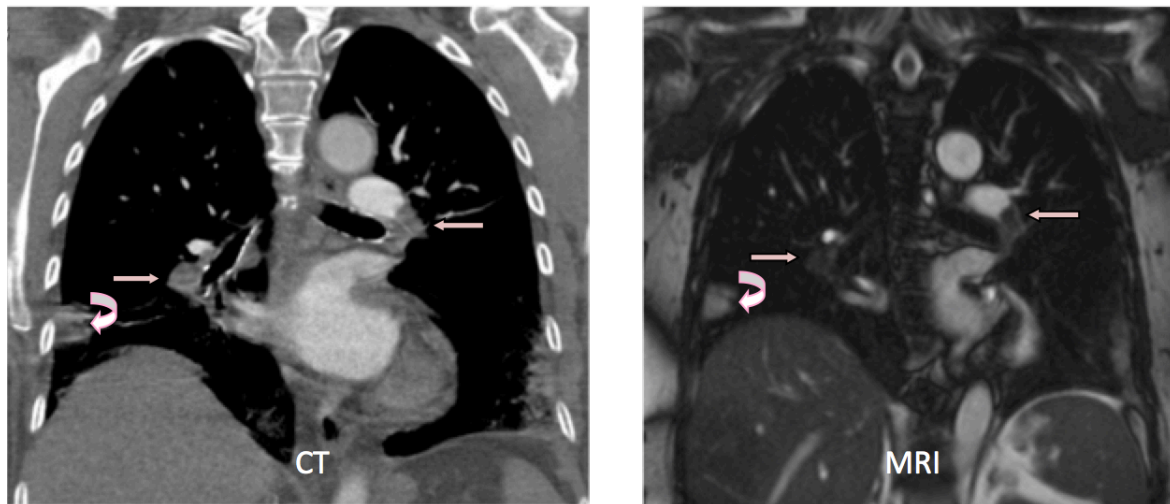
Examples of images from CTPA (left) and MRI (right) in a 83-year old patient with APE. Emboli can be seen in the right lower lobe artery and in the left intermediate artery (arrows), in addition an infarction can be seen in the right lung (bent arrow.)
